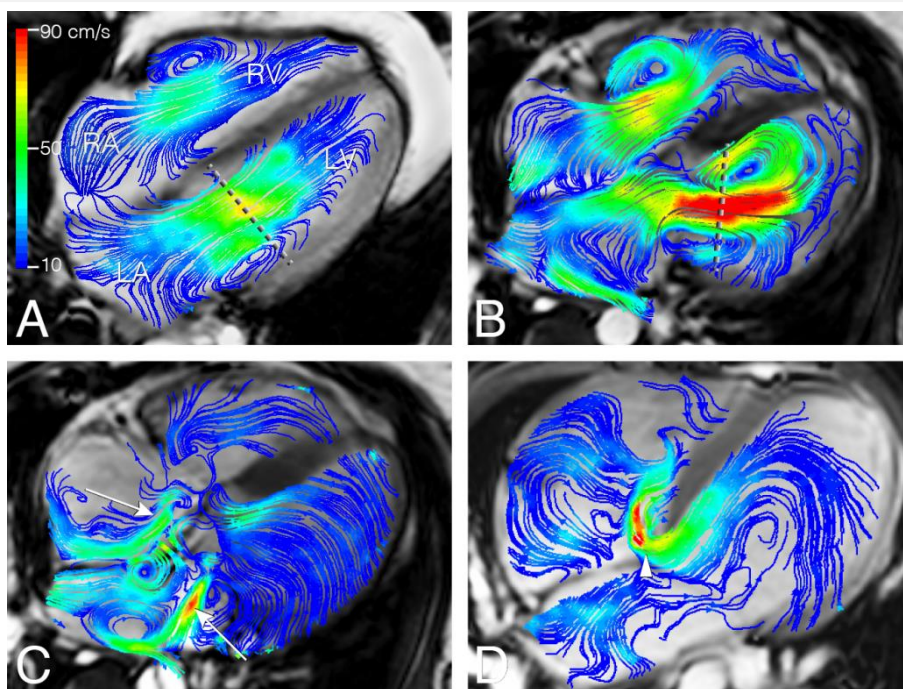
Left ventricular (LV) inflow assessment from 4D flow MRI and retrospective valve tracking. Streamline visualization with color coding of early LV inflow shows central inflow in a healthy volunteer (in A; 53 year old man) and a laterally directed inflow in a patient with corrected atrioventricular septal (AVSD) defect (in B; 26 year old woman). Positioning of the reformat plane is displayed by the dashed line. In C, eccentric regurgitant jets in both atrioventricular valves during systole in the same corrected AVSD patient are displayed (arrows). In D, shunt flow in an uncorrected AVSD is displayed (arrowhead) in a 24 year old male patient. LA: left atrium, LV: left ventricle, RA: right atrium; RV: right ventricle.
